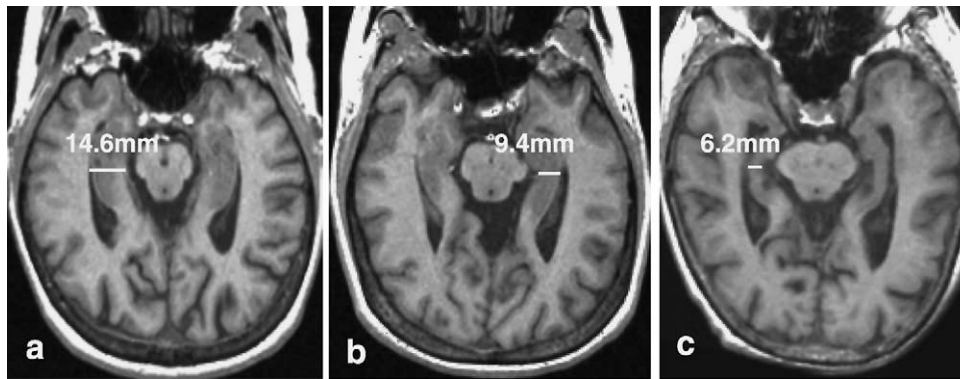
Comparison of the tMTL width between AD and control at the same level of the ICS with image orientation along the long axis of the hippocampus. MR images show tMTL width in a healthy control (a), a mild AD patient (b) and a moderate AD patient (c).
